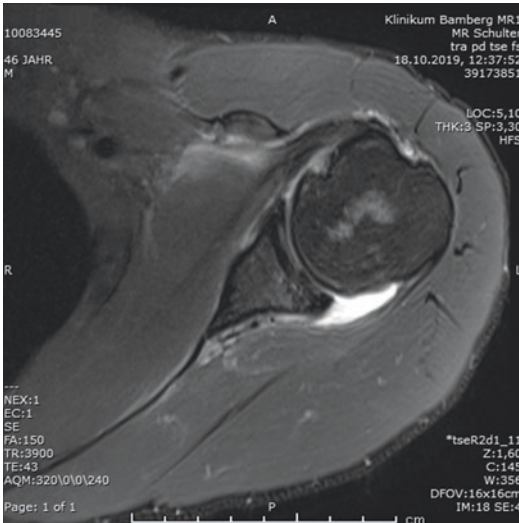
MRI of a shoulder with coracoid impingement
